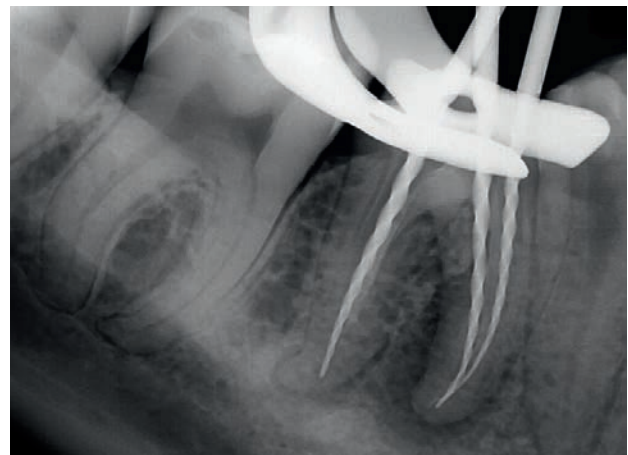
Rx with Niti CM instruments after root canal preparation. The foraminal exit of the distal root does not coincide with the radiographic apex.
